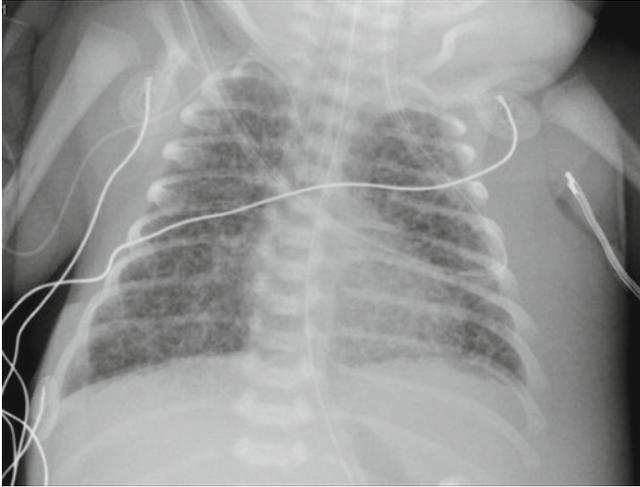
Bronchopulmonary dysplasia. Hyperventilated lungs with diffuse, bilateral interstitial coarse opacities and small cystic changes are the typical radiographic findings
